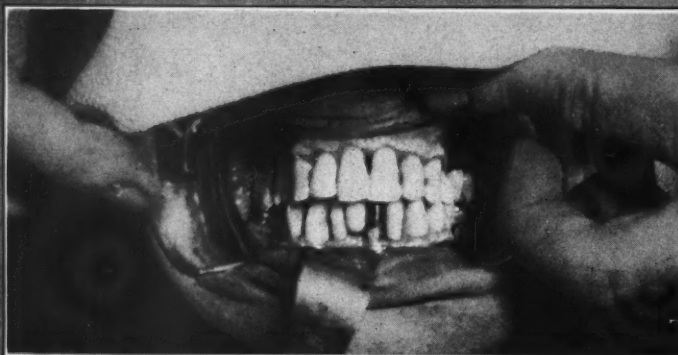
(A and B).—Appearance about one month after removal of the pack, the upper jaw being a few days older than the lower. Roentgenograms show a normal interproximal septum between the upper central incisors. Tissues were not disturbed at this point.
